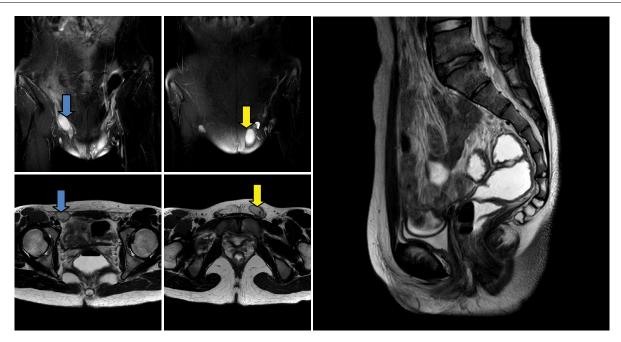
MRI ABDOMEN PELVIS t2 weighted showing the testicles annotated by blue (right side) and orange (left side) arrow (coronal and axial cuts) and complete absence of prostate, uterus, cervix and internal vagina (sagittal cut).
